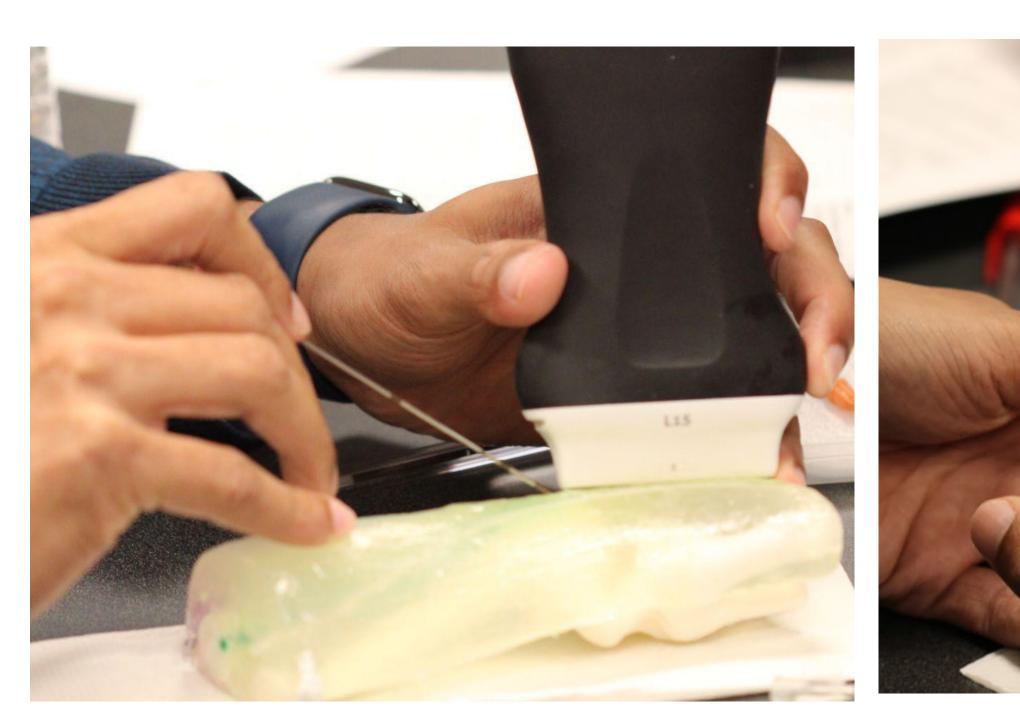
Ultrasound probes used in this study. A: Clarius L15HD3; B: Acuson VF8-3; C: Vevo 3100 MX700. A and B are clinical units, whereas C is a research use only ultra-high frequency system capable of visualizing nerve fascicles.
